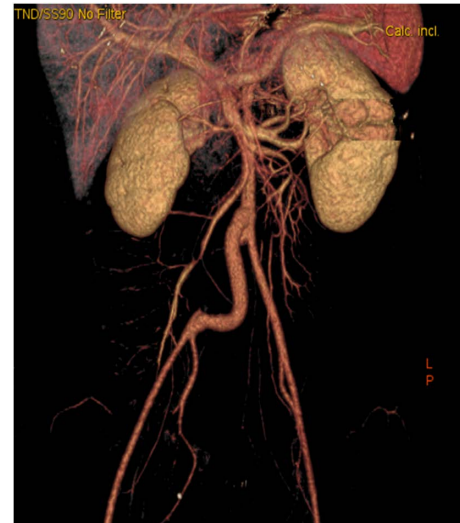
Postoperative computed tomography with contrast.
